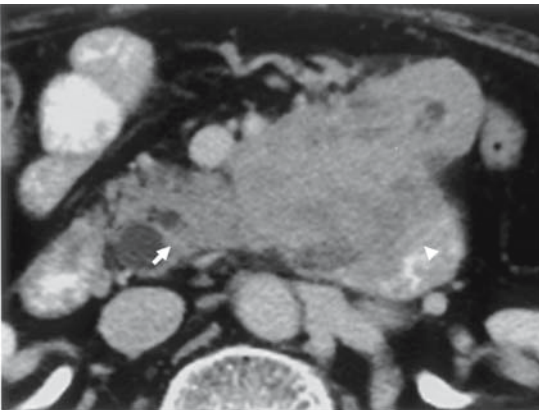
Imaging findings of a PET with rhabdoid features (CE-CT, early phase). A well-circumscribed mass (arrow) in the head of the pancreas appears to protrude into the body of the pancreas or the third portion of the duodenum (arrowhead). CE-CT imaging shows the tumor to be strongly enhanced in the early phase.
